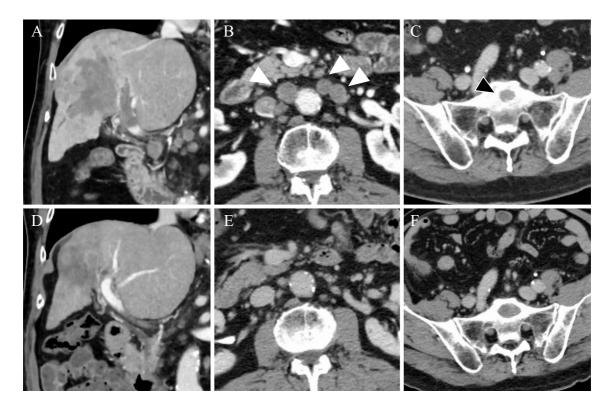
Computed tomography (CT) of hepatocellular carcinoma (HCC). (A) CT revealed diffuse-type HCC at both the right and portal vein tumor thrombi at the main portal trunk. (B) Multiple para-aortic lymph nodes were swollen (white arrowheads). (C) CT revealed osteolytic changes, indicating sacrum metastasis (black arrowhead). (D, E) After four cycles of atezolizumab plus bevacizumab, CT revealed that the intrahepatic lesions and lymph node metastases had markedly shrunk, and the portal vein thrombus had disappeared. (F) CT revealed slight progression of sacrum metastasis.
